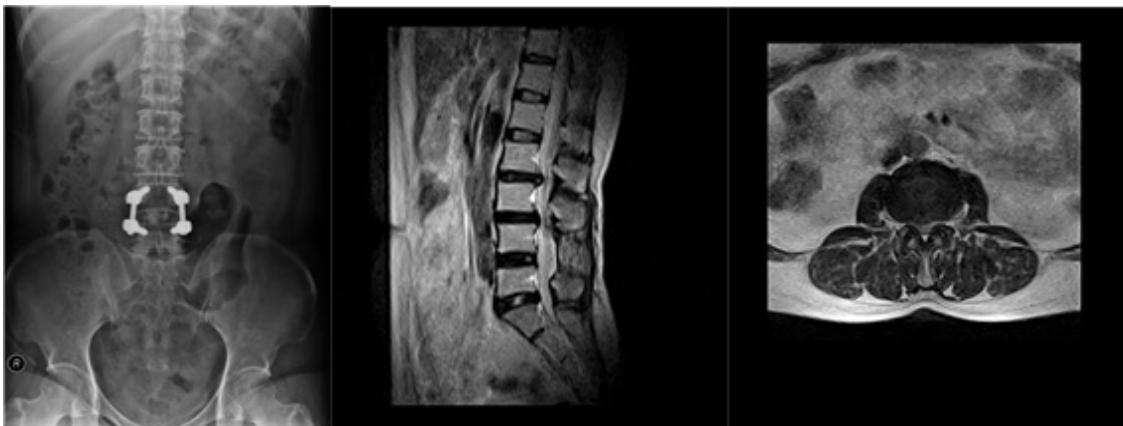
2014/02/25, Lumbar x-ray ap, sagittal image, L2-L3 axial image
